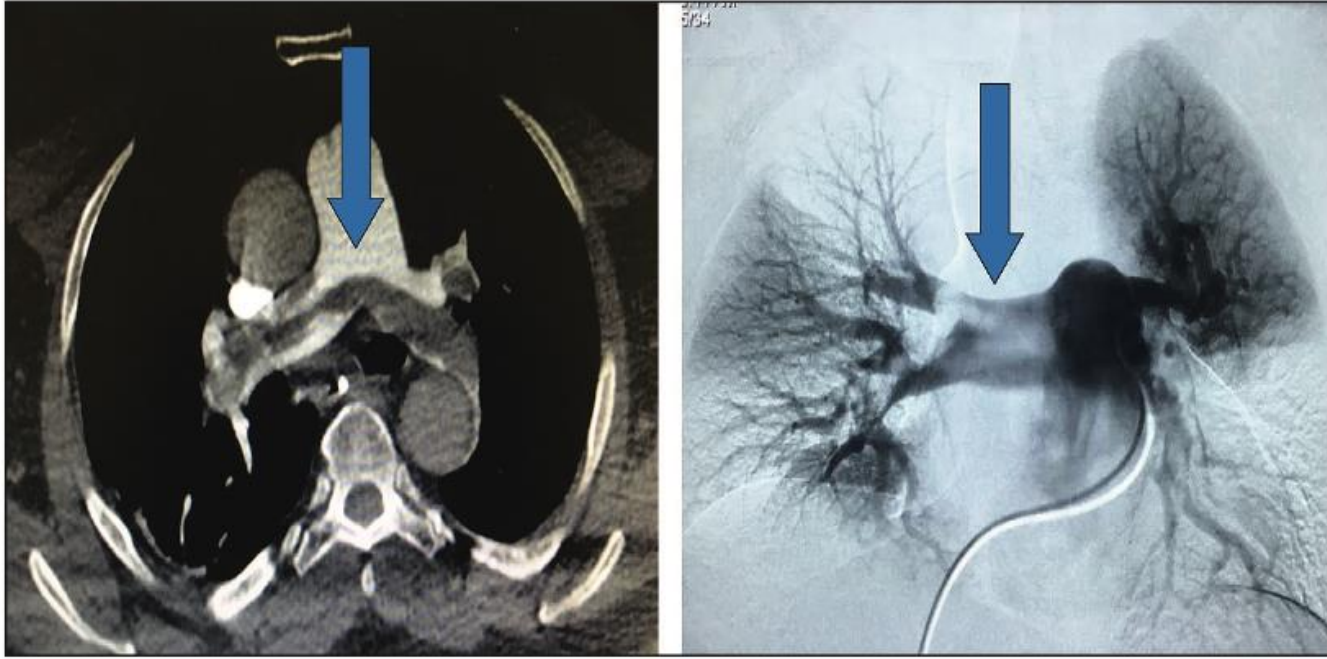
CT scan and pulmonary angiogram.
